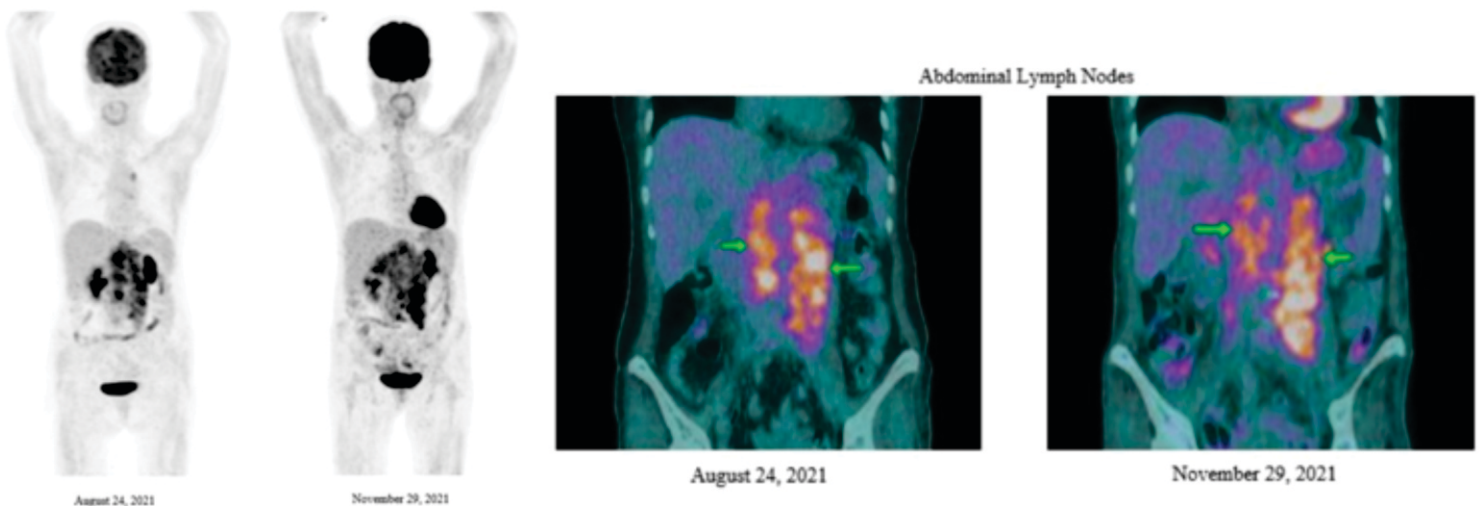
Comparative Whole body PET CT scan prior to initiation of chemotherapy dated August 24, 2021 and after 8 cycles of chemotherapy with Cisplatin + Etoposide dated November 29, 2021 showing multiple confluent paraaortic, aortocaval, pericaval lymph nodes.
